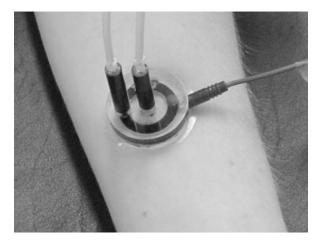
Laser Doppler flowmetry: Measurements of direct and indirect effect of vasoactive substance using single-point laser probes: One probe is used in direct contact with the iontophoresis solution chamber (colored ring) and measures the direct response. The center probe measures the indirect response (nerve axon-related effect). A small quantity (<1 ml) of 1% acetylcholine chloride solution or 1% SNP solution is placed in the iontophoresis. A constant current of 200 mA is applied for 60 s achieving a dose of 6 mC/cm⁻² between the iontophoresis chamber and a second non-active electrode placed 10–15 cm proximal to the chamber (black strap around the wrist). This current causes a movement of solution to be iontophoresed toward the skin
